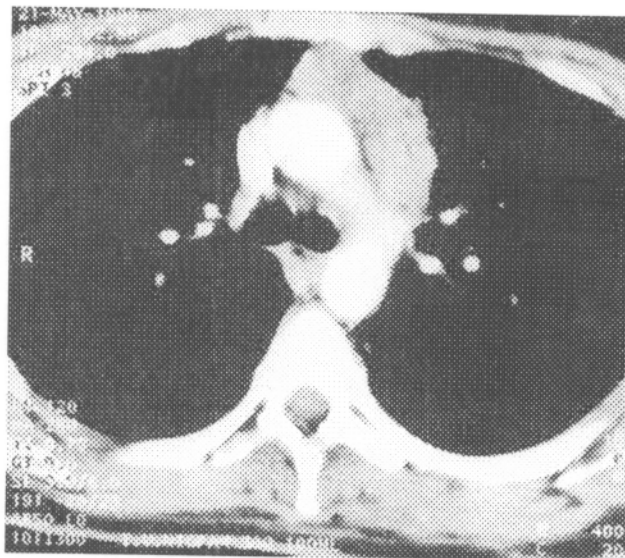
Computed tomogram of the patient in Fig. 1 showing the thymic carcinoma anterolateral to the ascending aorta and inferolateral to the aortic arch.
